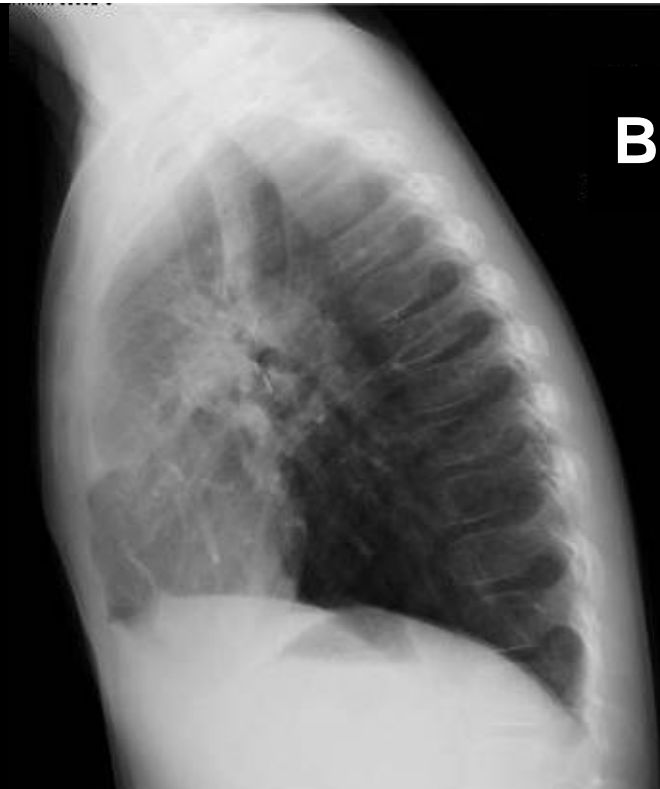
Chest X-ray 6 months after transplantation in maximal inspiratory (A: frontal view, B: lateral view) and expiratory (C: frontal view, D: lateral view) states.
